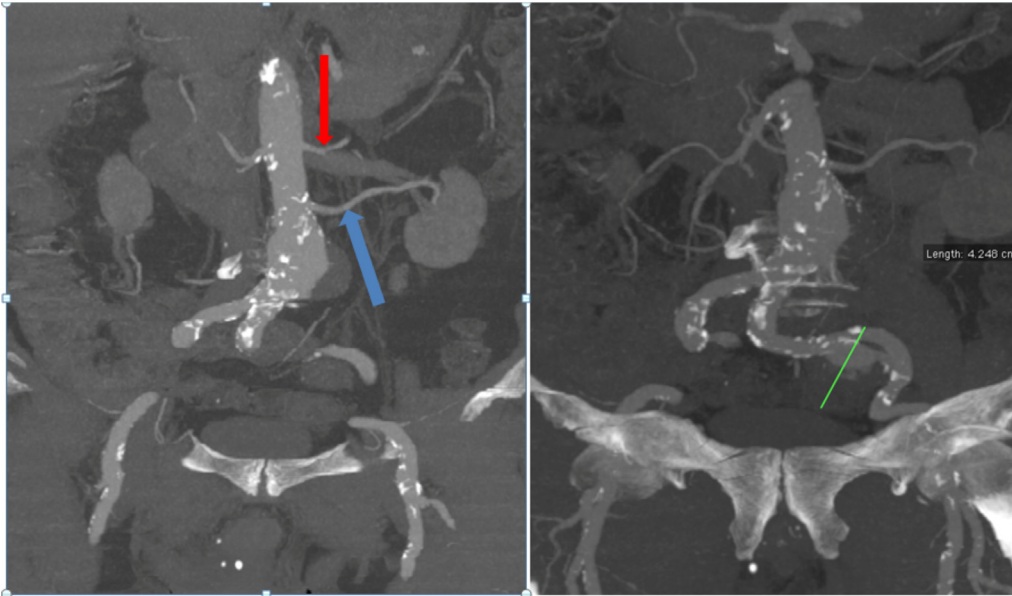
Preoperative CT-angiography demonstrates an infrarenal aortic aneurysm of a 51-mm diameter accompanied by a 42-mm aneurysm of the left common iliac
